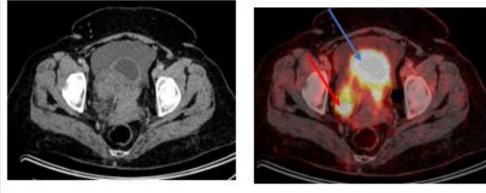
A Hypermetabolic active metastatic serosal nodule in image (b) of SUV max 9.5 which could not be identified on the corresponding CECT alone in image (a)(arrow).
